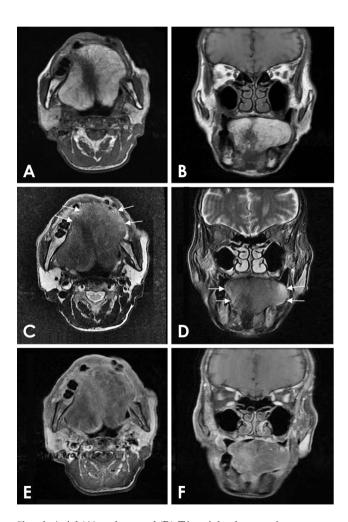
Axial (A) and coronal (B) T1-weighted magnetic resonance (MR) images demonstrate well-defined homogeneous hyperintense masses of the tongue. Axial (C) and coronal (D) fat-suppressed T2-weighted MR images show tumors with iso-signal intensity and a partially hyperintense margin (arrows). Axial (E) and coronal (F) fat-suppressed enhanced T1-weighted MR images reveal no enhancement within the masses.
